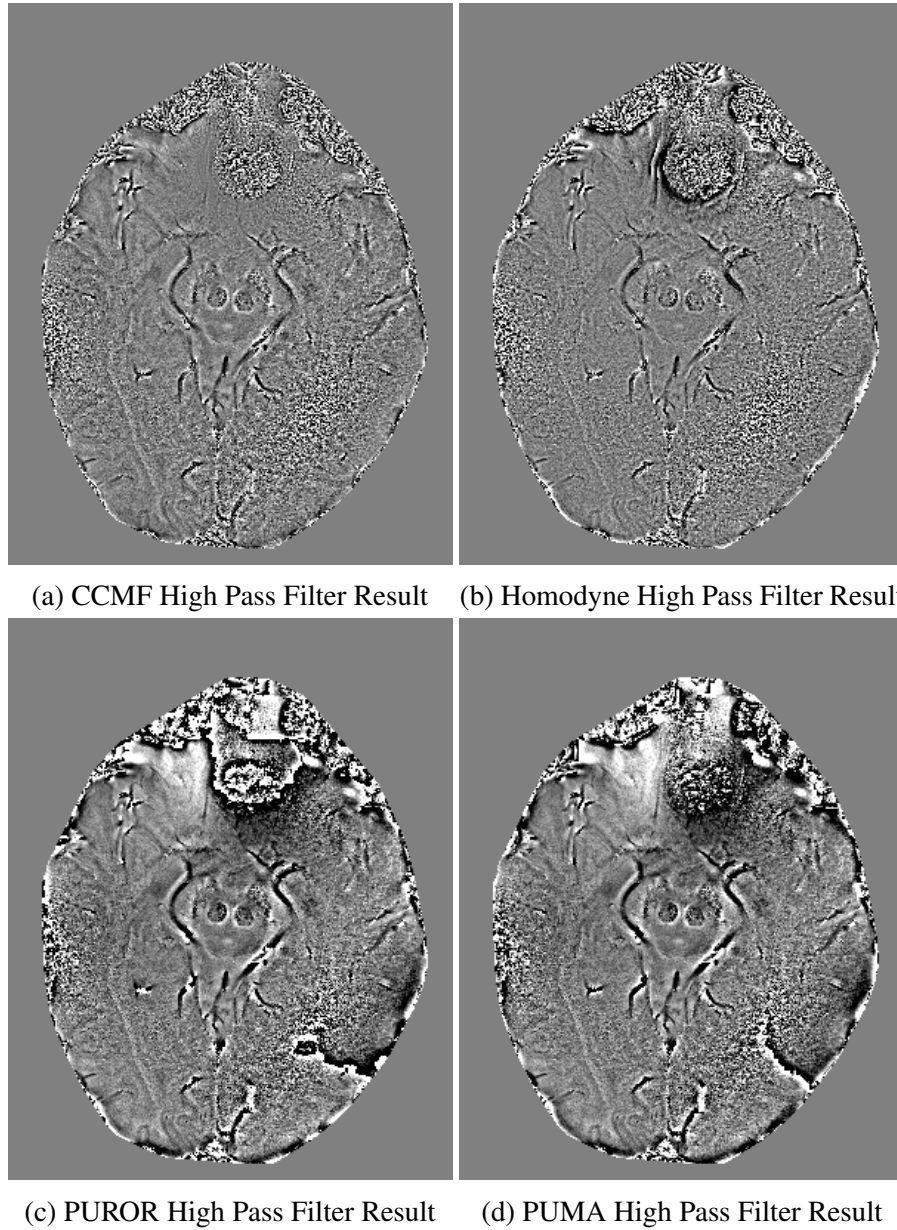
Local phase shift maps on the single channel MR image shown in Figure 2.11.
